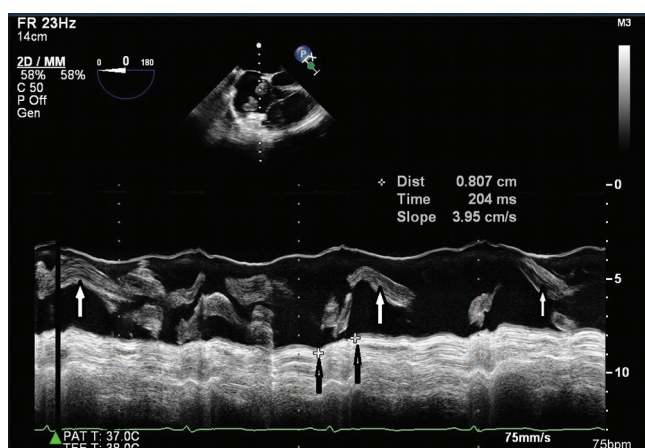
M-mode echocardiography showing tricuspid annular plane systolic excursion of 0.8 cm (black arrows) and thrombus in the right atrium (white arrows)
